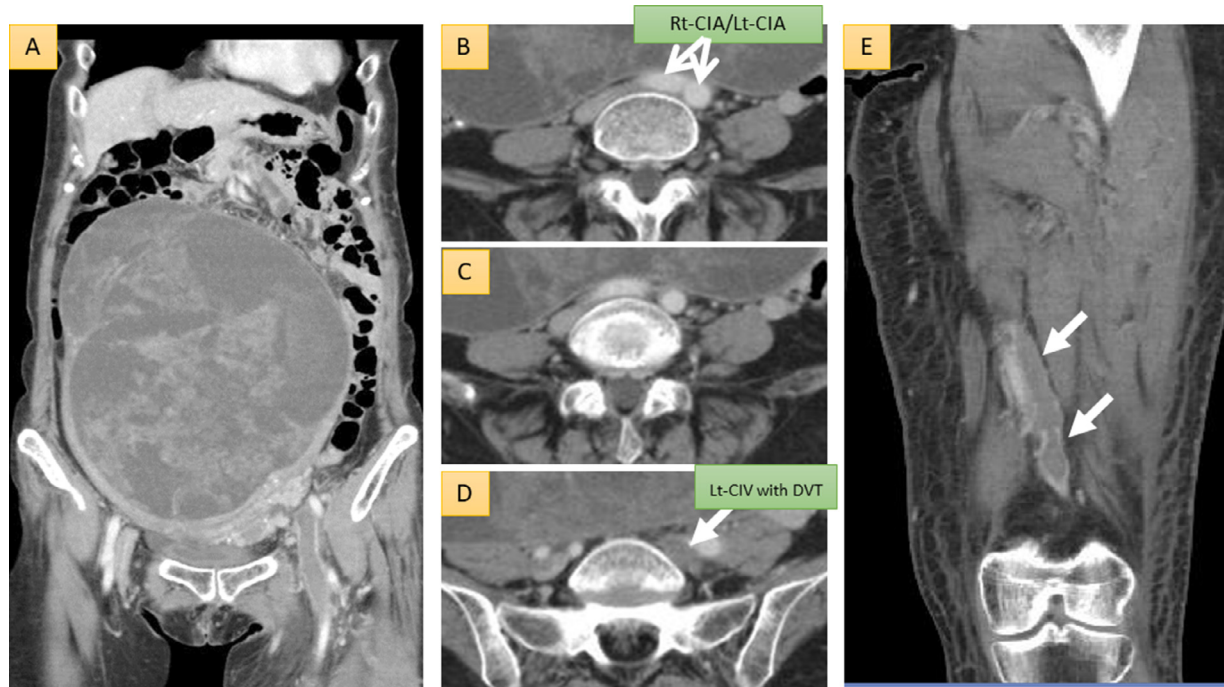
Enhanced computed tomography on admission. (A) Coronal view of the whole abdomen, (B–D) axial views, demonstrating the common iliac vein and artery at the level of the fifth lumbar vertebra as well as an occlusive thrombosis of the left common iliac vein (white arrow), and (E) coronal view of the left thigh, revealing an occlusive thrombosis of the left superficial femoral vein (white arrow).
